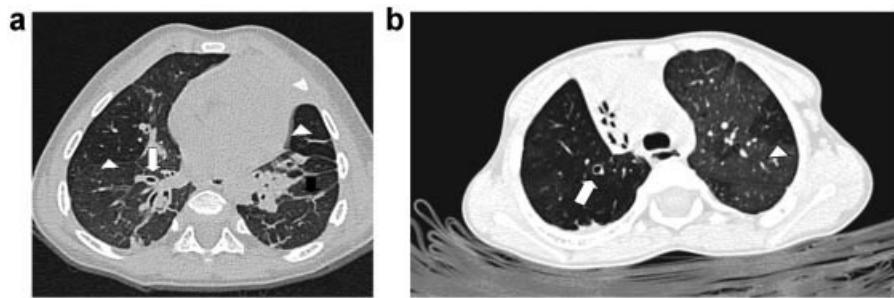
a: 13 months old boy with severe BPD. Inspiratory axial CT showing regions of attenuation (arrowheads), parenchymal linear opacities (black arrow), bronchial wall thickening, and bronchiectasis (white arrow). b: 3 years old girl with severe BPD. Inspiratory axial CT showing regional attenuations (arrowheads). The pulmonary vessels caliber in those areas are smaller. Bronchiectasis (white arrows) is also noted.
